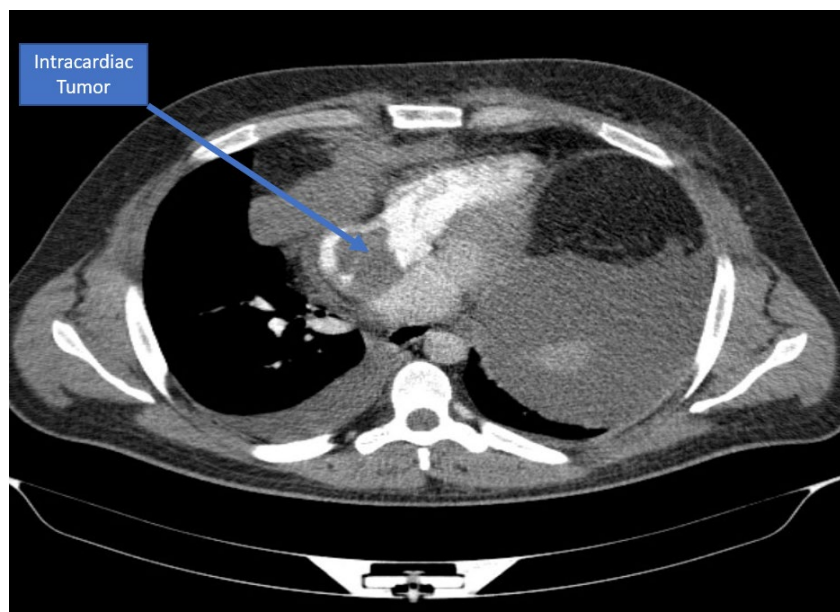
Intracardiac tumor, contrast enhanced CT scan
